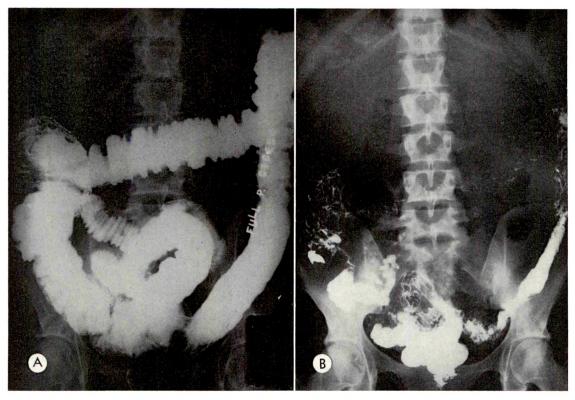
October, 1961: (A) Barium enema study. The ascending and transverse portions of the colon show areas of narrowing and incomplete filling which on roentgenoscopy were found to be inconstant and variable. The descending colon and sigmoid are tubular in character, ahaustral, and present numerous superficial projections from the lumen. (B) Postevacuation study. Only small amounts of the opaque material are retained in the colon. The mucosa is abnormal in appearance, the folds being coarse and nodular.
